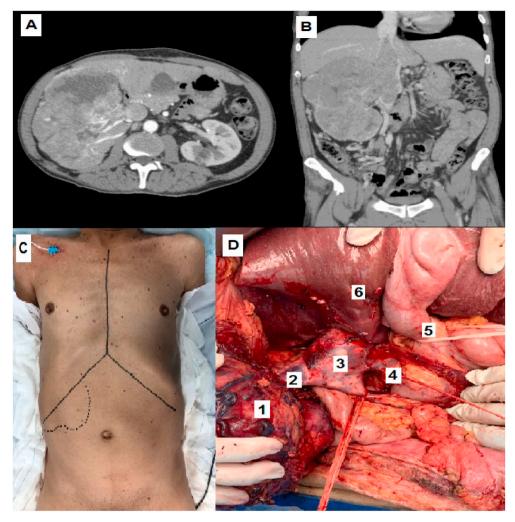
A) Axial section of abdominal CT. B) Coronal section of abdominal CT. C) Surgical access. D) Intra-operative strategy: 1 = Right Kidney; 2 = right renal vein with intraluminal thrombus; 3 = exposure of the inferior vena cava with the presence of a thrombus; 4 = preserved left renal vein; 5 = Pringle maneuver; 6 = batting liver.
